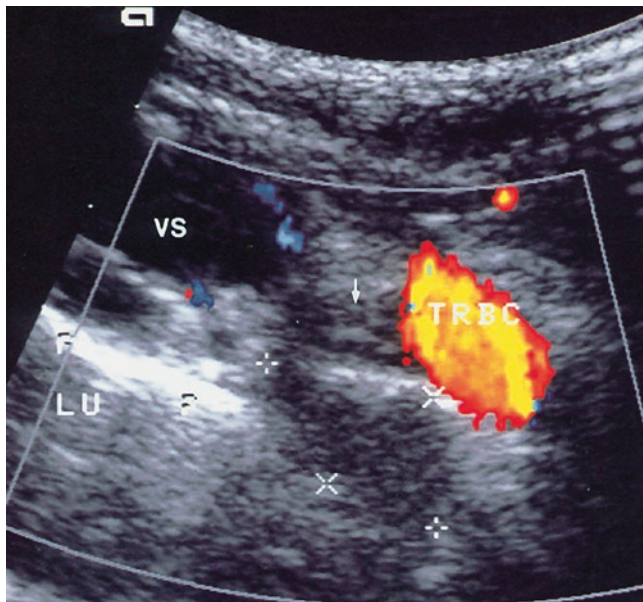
Lymph node tuberculosis. Suprasternal semisagittal section, *right*. Dorsally to the color-Doppler sonography image of the brachiocephalic trunk (*TRBC*), one can see a hypoechoic, indistinctly delineated lymph node (*crosses*) in the paratracheal region, which normally has a homogeneous, hyperechoic structure. The diagnosis of lymph node tuberculosis was made possible by color-Doppler sonography of the fine-needle puncture. *LU* lung
